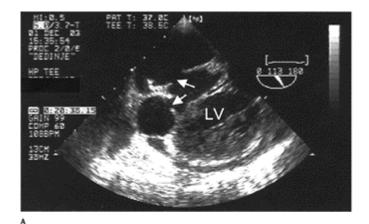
Double pseudoaneurysm. (A) Transesophageal echocardiography: modified longitudinal, two-chamber view. Discontinuity of the inferoposterior myocardial wall at two separate places (arrows), with two narrow-neck aneurysmal sacs, indicating pseudoaneurysm formation. LV: left ventricle. (B) Intraoperative findings: double myocardial rupture (arrows). (Reproduced from Milojević P et al. J Thorac Cardiovasc Surg 2004; 128:765–7. 47 © 2004 with permision
